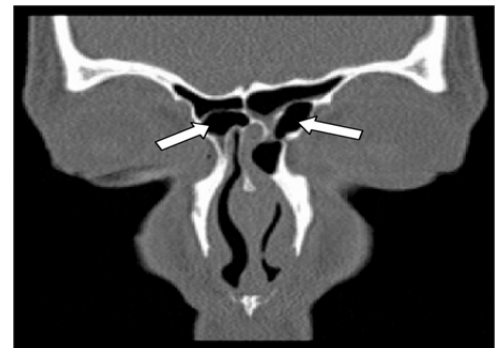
CT scan PNS coronal section showing hypoplastic right Frontal sinus.
